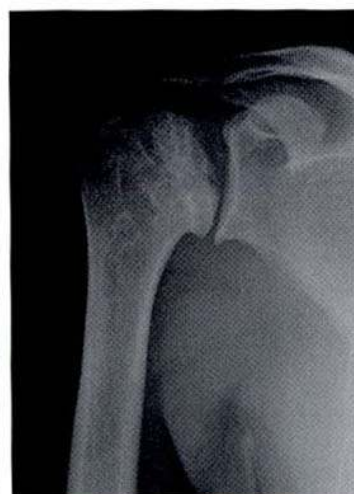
Type A5 DON on the X-ray
